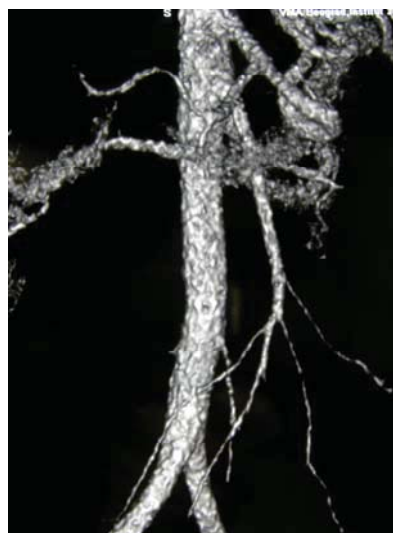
Postoperative multislice computed tomography (MSCT) angiography – the normal trunk of superior mesenteric artery
